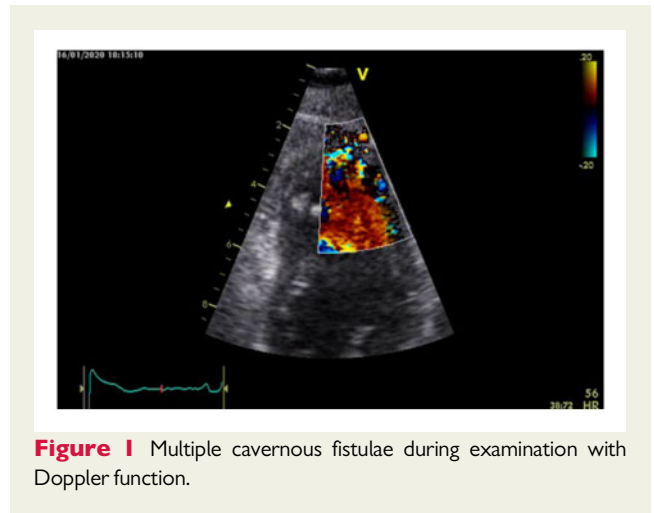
Multiple cavernous fistulae during examination with Doppler function.
